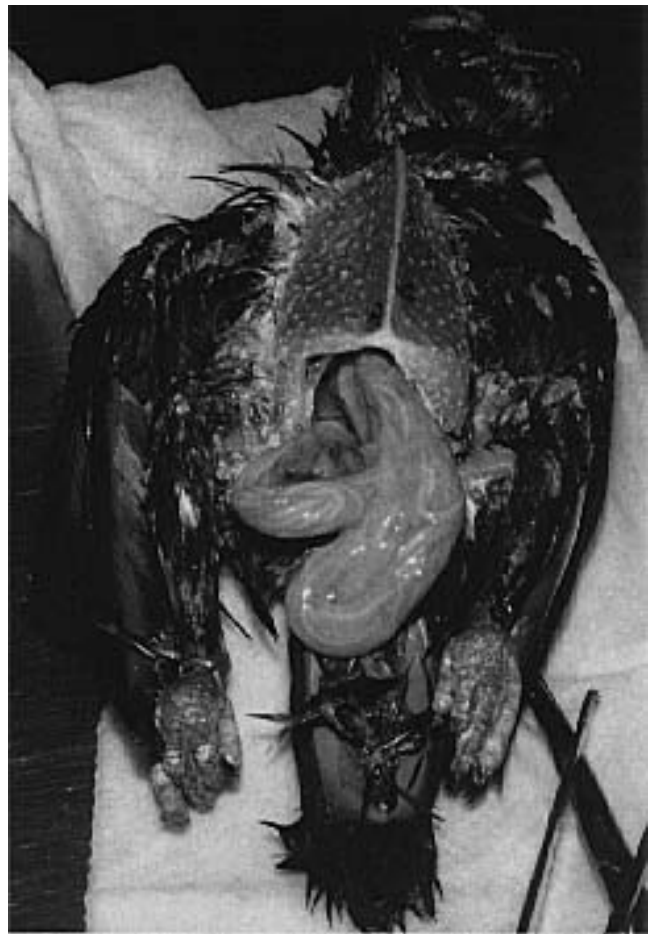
A two-year-old Severe Macaw was presented with vomiting, diarrhea and chronic weight loss, even though the bird had a voracious appetite. The bird had lost most of its pectoral muscle mass (weight 230 g), and had a distended abdomen. Radiographs indicated enlarged bowel loops, diffusely filled with linear soft tissue densities. A fecal exam revealed thousands of ascarid eggs. The bird did not respond to supportive care. This bird was maintained in a mixed species outdoor exhibit with access to the ground. Intestinal nematodes are rare in companion birds maintained indoors and in aviary birds maintained in suspended enclosures.
